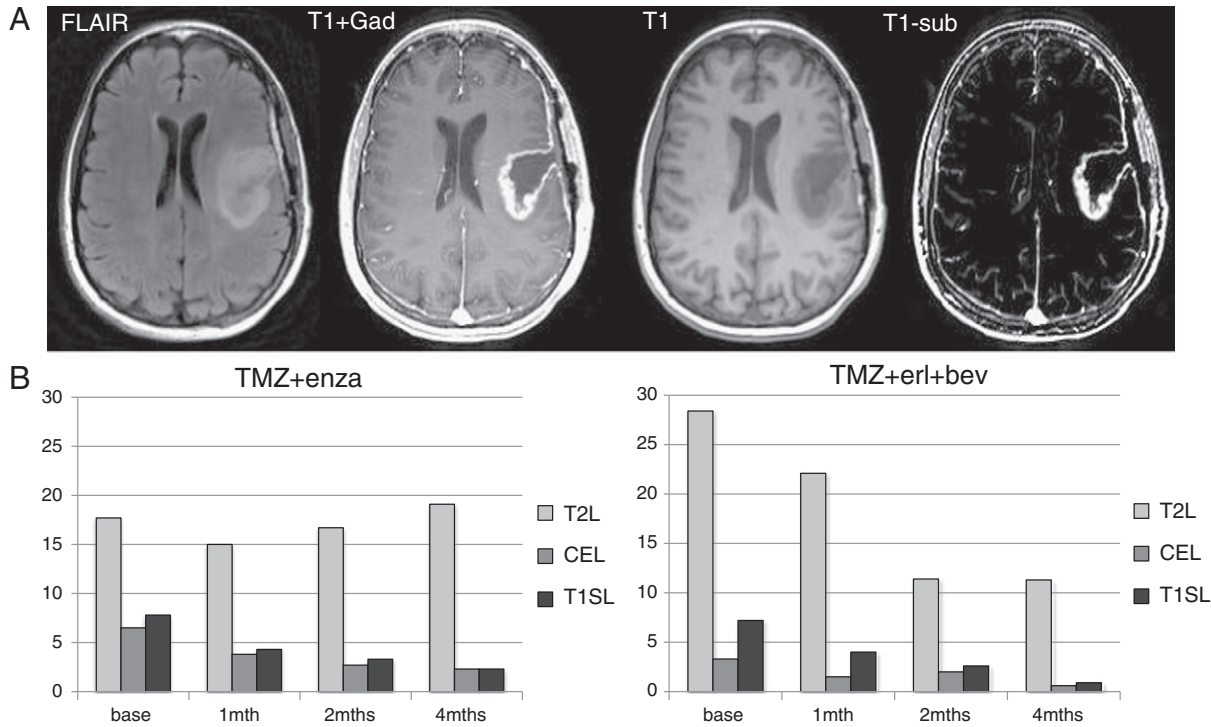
The images in (A) show baseline FLAIR, T1-Gad, T1, and T1S images from one subject. The bar plots in (B) show the time course of changes in median volumes of the CE, T2, and T1S lesions for patients with all four scans. These show the differences in lesion volumes and the patterns of changes in follow-up scans.
